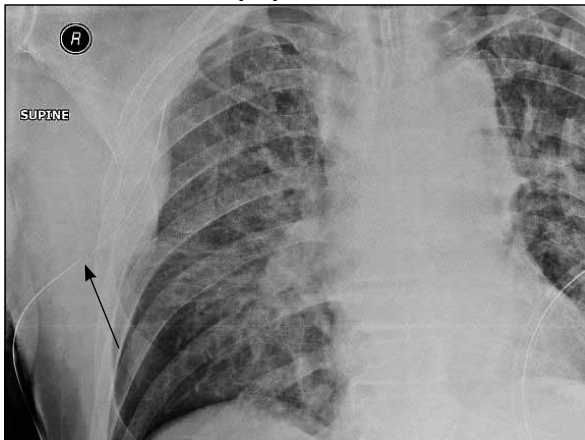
Chest X-ray showing a right intercostal chest drain in situ. The tip is lying within the pneumothorax, but the drainage hole lies outside of the pleural cavity within the subcutaneous tissues (arrow). The intercostal chest drain tube needs to be re-sited and the chest X-ray repeated.
